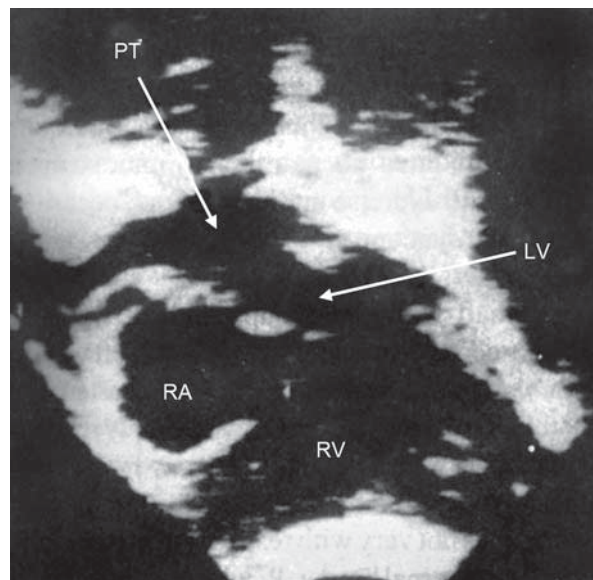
Echocardiography (two-dimensional) in transposition of the great arteries.
